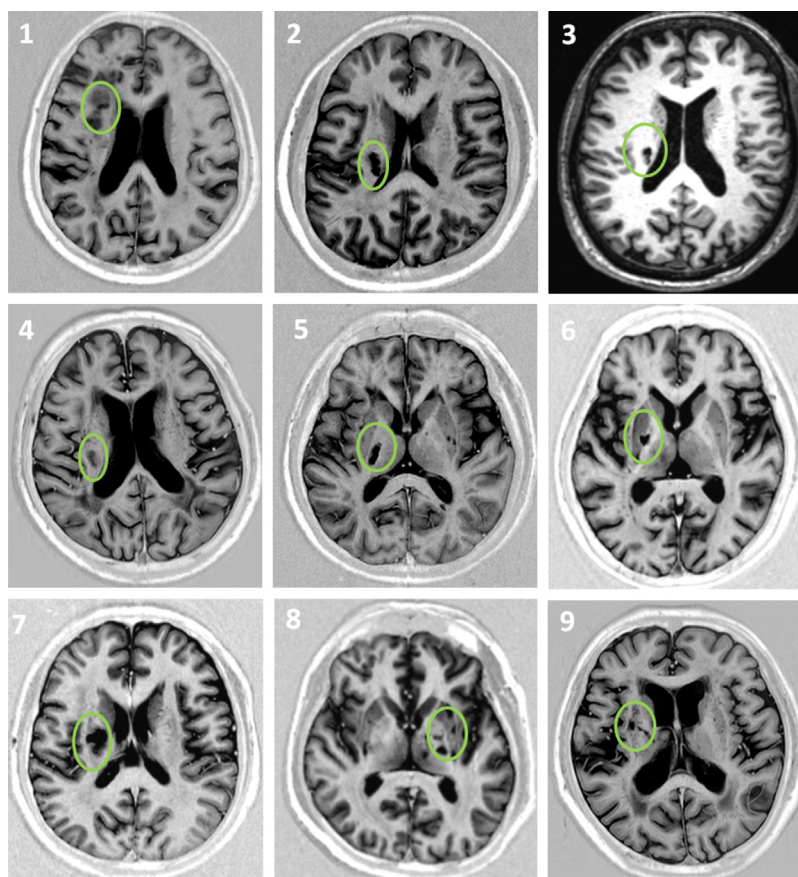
Axial T1-weighted image for each patient, in which the infarct area was circled by an experienced radiologist. The numbers correspond with the patient ID in Table 1. Image 3 was obtained using FFE sequence due to missing MPRAGE data. All the other images were acquired using MPRAGE sequence.
